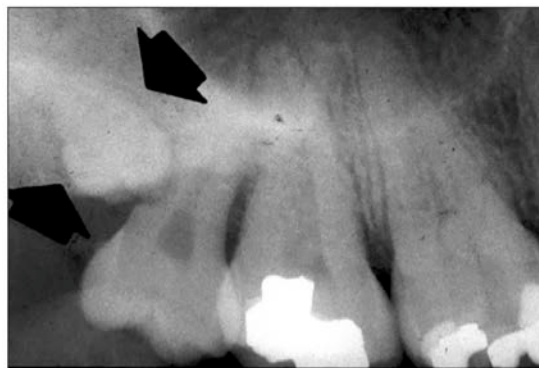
Periapical radiograph of a maxillary distomolar.
